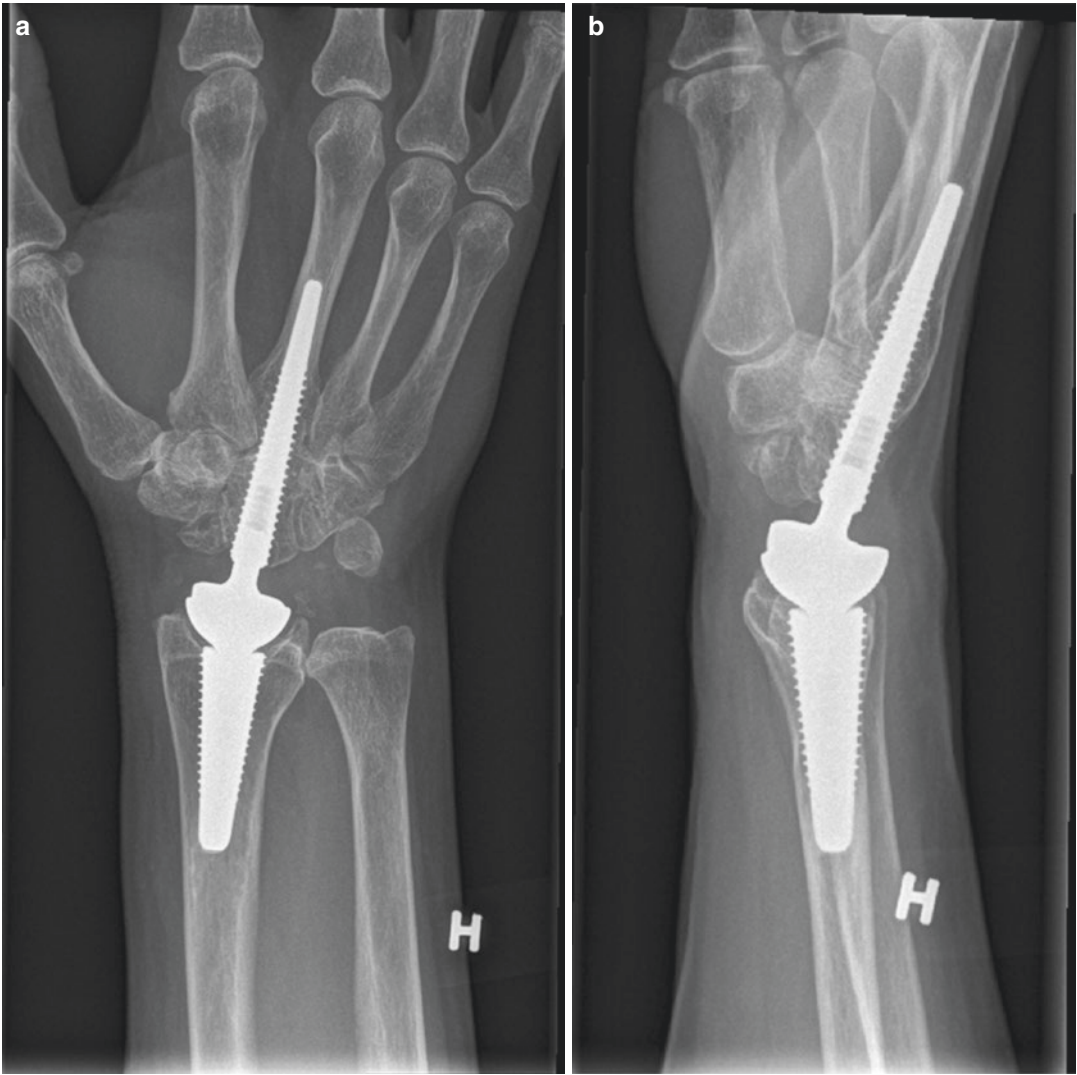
(a) Posteroanterior and (b) lateral radiographs of the Motec total wrist, 5 years following implantation. (Courtesy, Ole Reigstad, MD, 2020)
